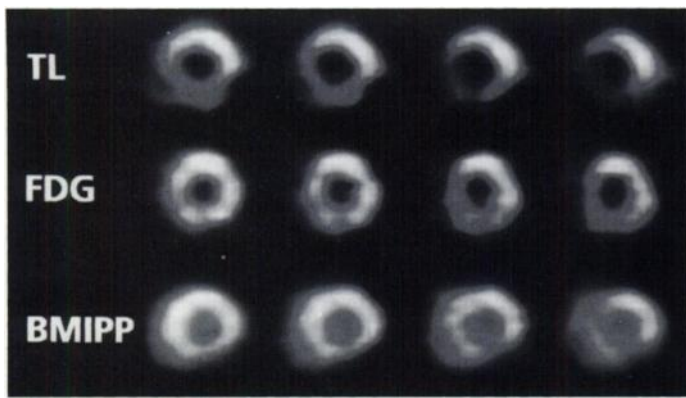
Myocardial short-axis slices of a patient (62-yr-old man) with three-vessel disease without a previous infarction, showing both a FDG/Tl and a BMIPP/Tl mismatch in the inferior wall (right coronary artery = 99% stenosis).
